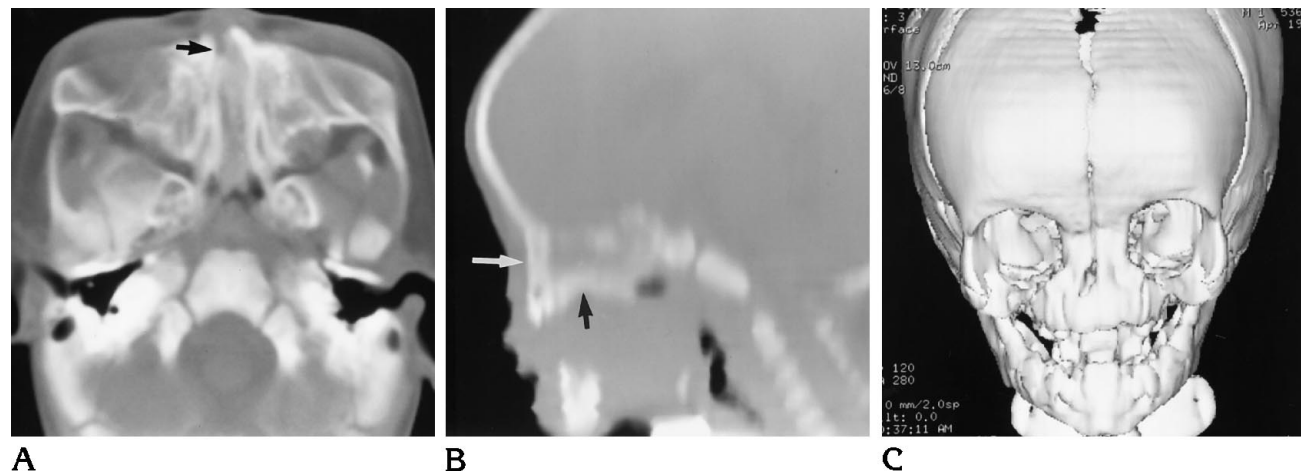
A, Axial CT scan shows blind-ending right nostril (*arrow*). Piriform aperture is narrowed and nasal cavities are filled by a combination of soft tissue/bone density. The nasal cavities are also narrowed.
